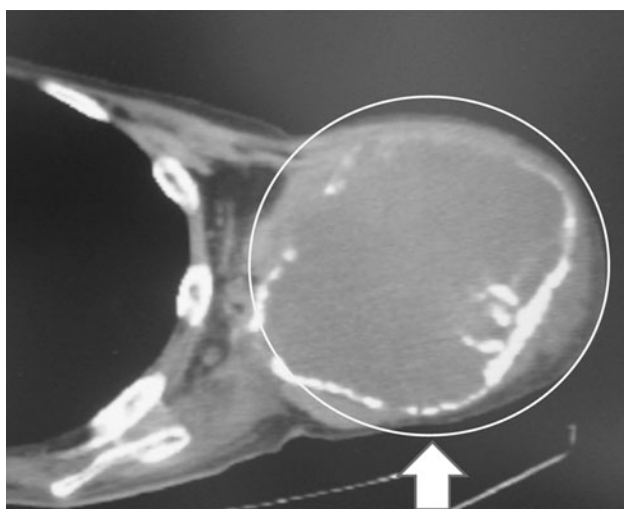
Computed tomography image of a bone metastasis invading the axillary region of the left brachial plexus (arrow)
